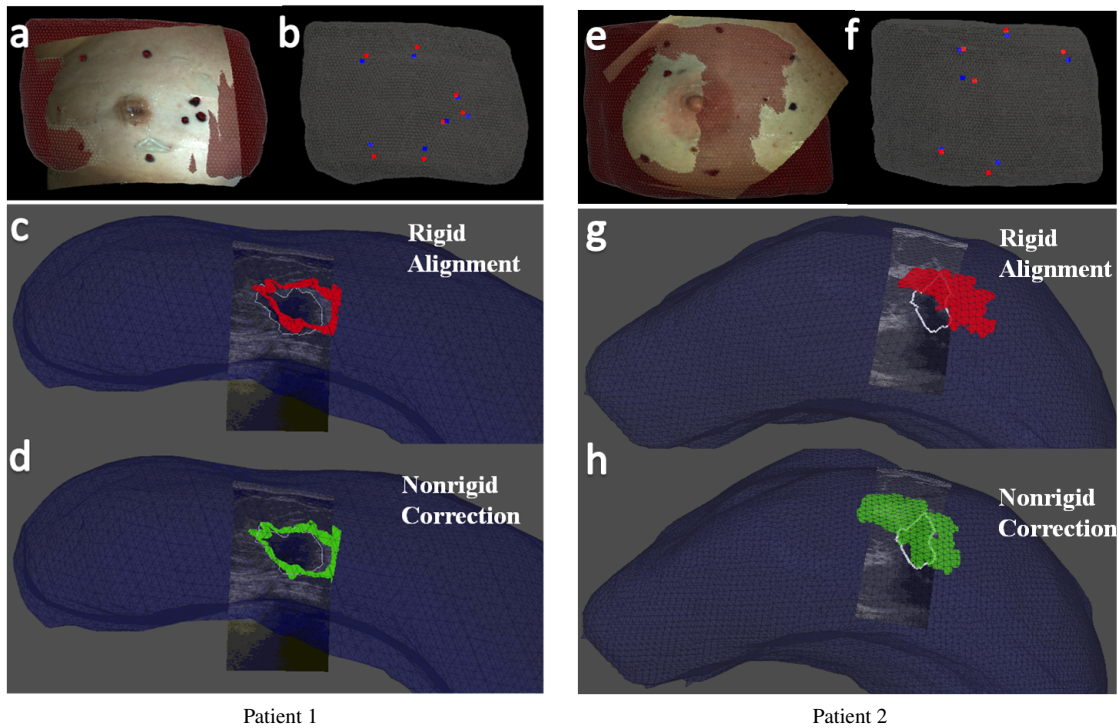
9: Patient 1(a-d) and Patient 2 (e-h). (a,e) co-registered textured point cloud and preoperative mesh. (b,f) co-registered preoperative fiducials (red) and intraoperative fiducials (blue). (c,g) intraoperative ultrasound image with white tumor contour overlaid on preoperative rigid aligned tumors in red. (d,h) intraoperative ultrasound image with white tumor contour overlaid on preoperative nonrigid corrected tumors in green.
